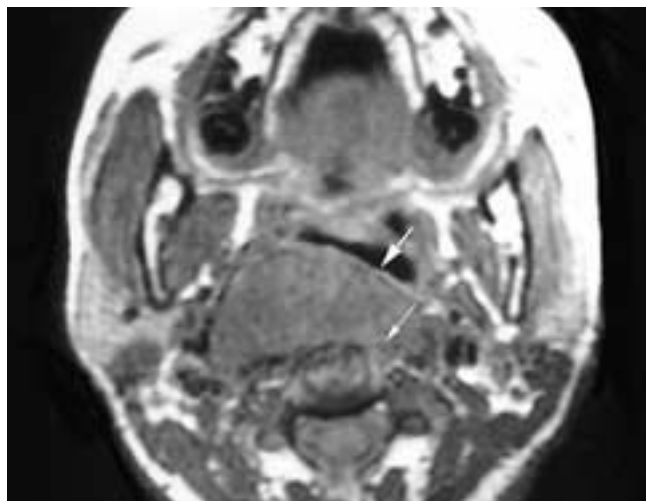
Axial T1-weighted MR image shows a mass involving the flexor muscles of the cervical spine (small thinner arrow) and pushing the pharyngeal constrictors forward (large arrow). This schwannoma was in the prevertebral space, pushing the danger and retropharyngeal spaces forward. Because the actual fascia (prevertebral, alar, and visceral) cannot be routinely seen on imaging, the involvement of the prevertebral muscles indicates the space of origin of the mass.
